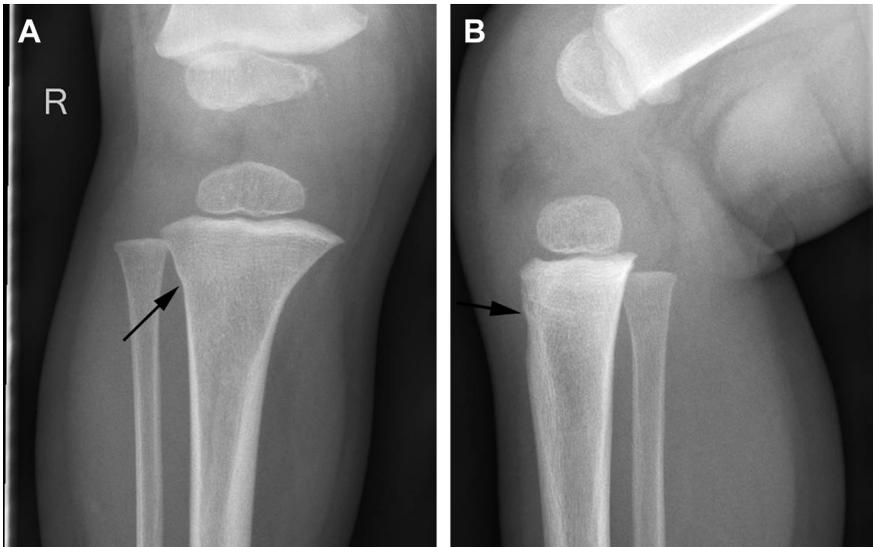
(A) AP radiograph of the right knee in a 24 month old with limp demonstrates a subtle buckle fracture (*arrow*) at the proximal tibia near the tibial tubercle. (B) Lateral radiograph of the right knee in a 24 month old with limp demonstrates a subtle buckle fracture (*arrow*) at the proximal tibial tubercle.
